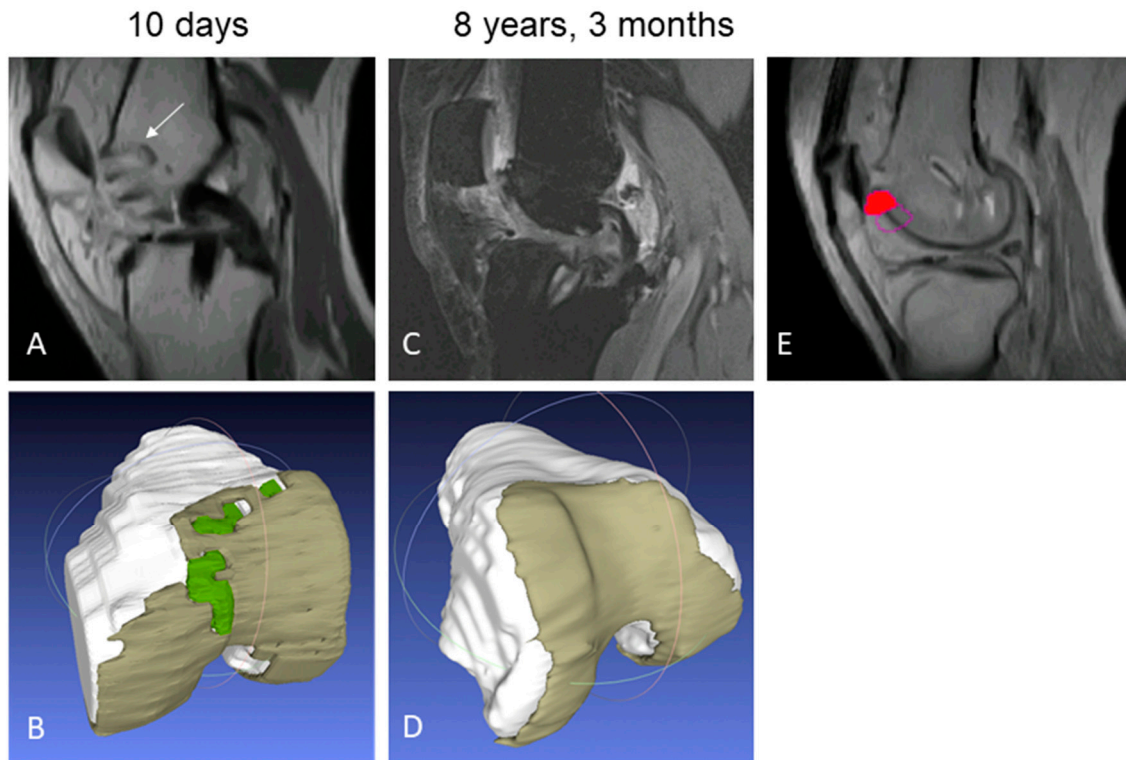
Longitudinal MRI reconstruction of a ChondroMimetic-treated subject knee at 10 days (A,B) and 8 years, 3 months (C,D). (A) By 2D MRI, 5 ChondroMimetic implants can be observed with hyper-intense peri-implant boundaries, and lack of cartilage-like signal (white arrow). (B) 3D rendering of knee yields ChondroMimetic implants (green) surrounded by cartilage (brown) by automated software based on MRI signal. (C) At the follow-up after 8 years and 3 months, treated bone defects are filled with bony repair tissue and the treated cartilage defect is filled with cartilaginous repair tissue. (D) Automated rendering demonstrates cartilaginous tissue in repaired defects congruous with surrounding cartilage. (E) The trochlear control region of interest (filled red circle) of native cartilage used for T2 relaxation time comparison. The open purple circle shows an unused, alternate control region of interest.
